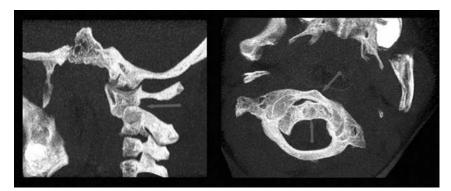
Sagittal and axial CT scans showing atlantoaxial rotatory subluxation of C1 on C2 with narrowing of the spinal canal.
